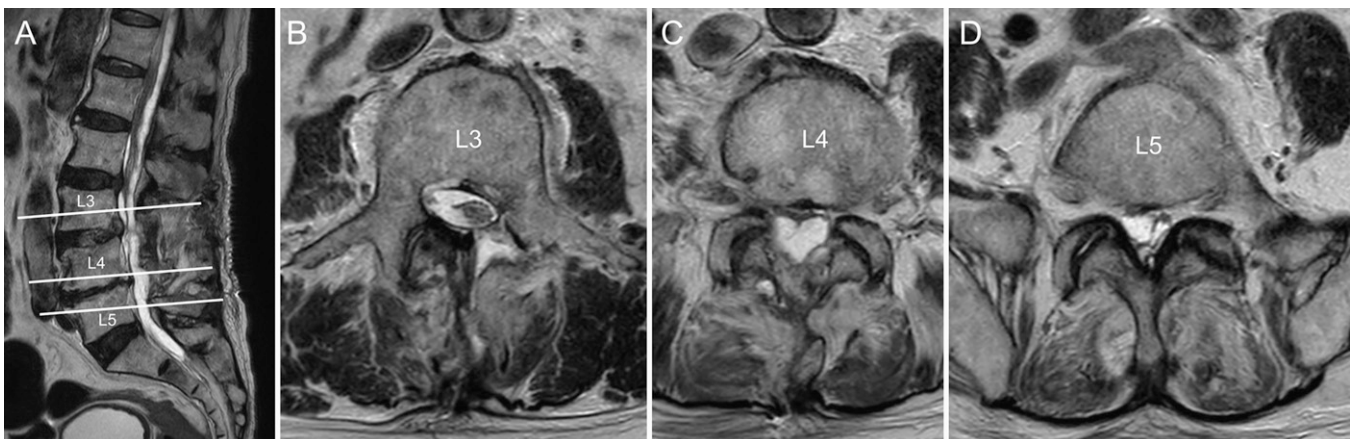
One-week postoperative sagittal T2-weighted (A) and axial (levels of the white lines in panel A) T2-weighted (B–D) MRI shows spinal nerve deviation to the ventral side due to SSEH from T12 to S1.
